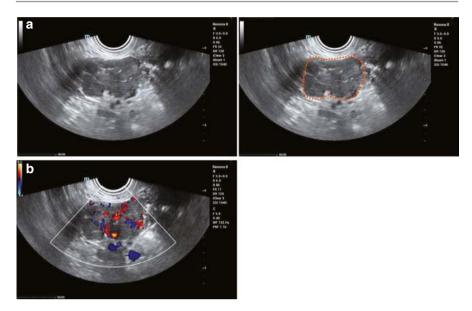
(a) Ultrasound shows a solid, internally hypoechoic mass with unclear borders and irregular morphology. The tumor is circled in orange. (b) Color Doppler ultrasound shows abundant blood flow signals within the tumor
